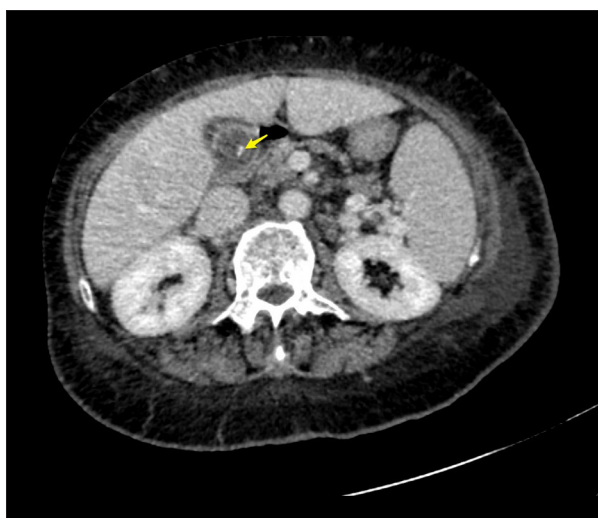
Abdominal computed tomography scan demonstrating a solitary gallstone (yellow arrow) without evidence of acute cholecystitis.
